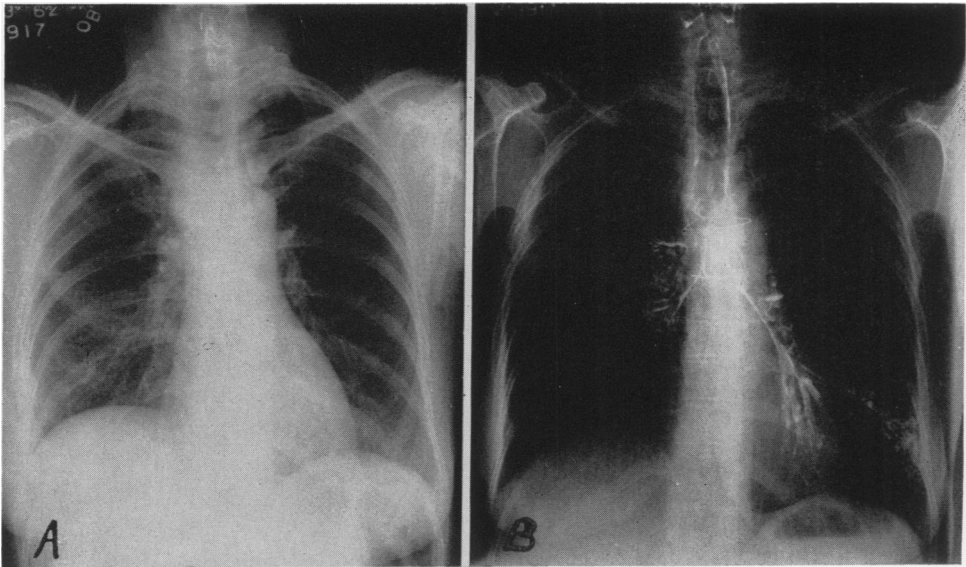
(Case 1). A. Postoperative roentgenogram. B. Postoperative tracheobronchogram.
